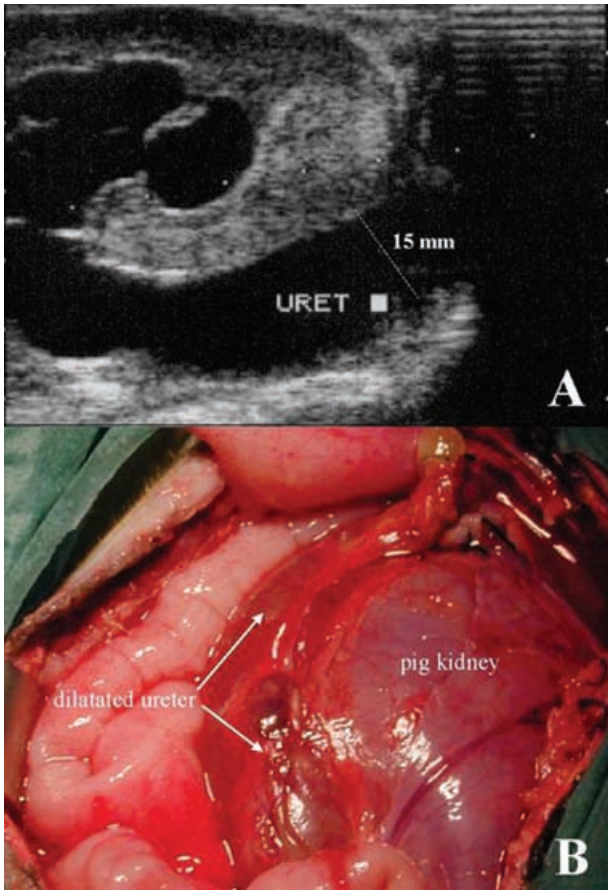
Ureteral stenosis was diagnosed by ultrasound and confirmed by surgical exploration. (A) Ultrasonography of obstructed ureter with pelvicalyceal and upper ureter dilatation. (B) Confirmation of ureteral dilatation by surgical exploration.
